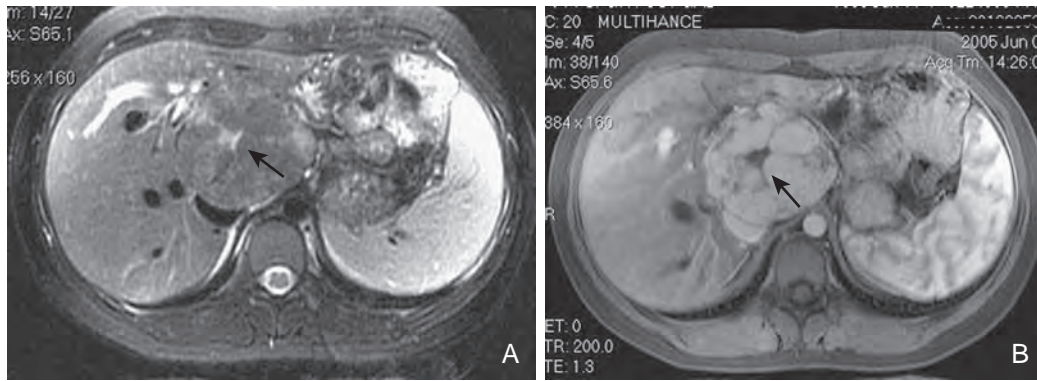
Focal nodular hyperplasia: MRI features. A. A large lesion is seen on this T2-weighted image obtained with fat suppression. The lesion is isointense to the normal liver, and the central scar is hyperintense (arrow). B. Gadolinium-enhanced early arterial phase demonstrates homogeneous enhancement of the lesion. The central scar (arrow) does not enhance early.
